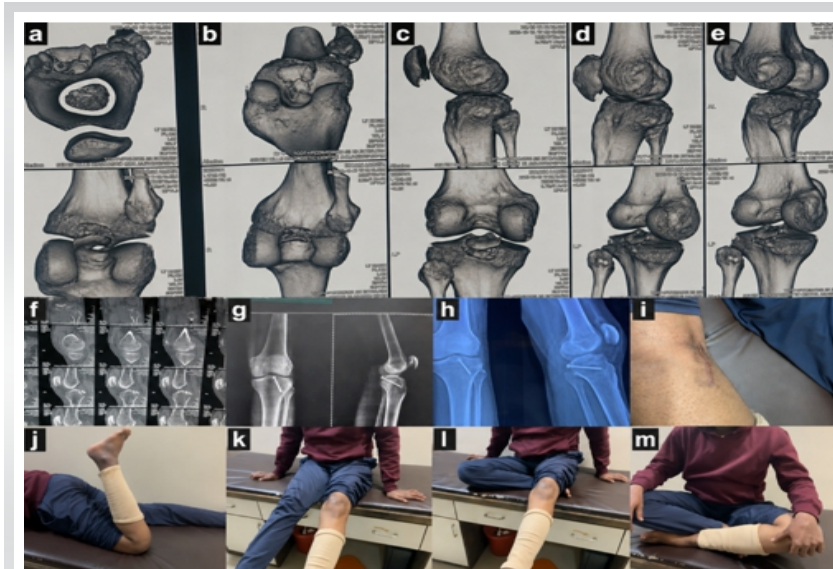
(a, b, c, d, e, f) pre-op workup; (g and h) post-op X-rays; (i) mini-incision; (j, k, l, m) showing range of motion on 8-week follow-up.
